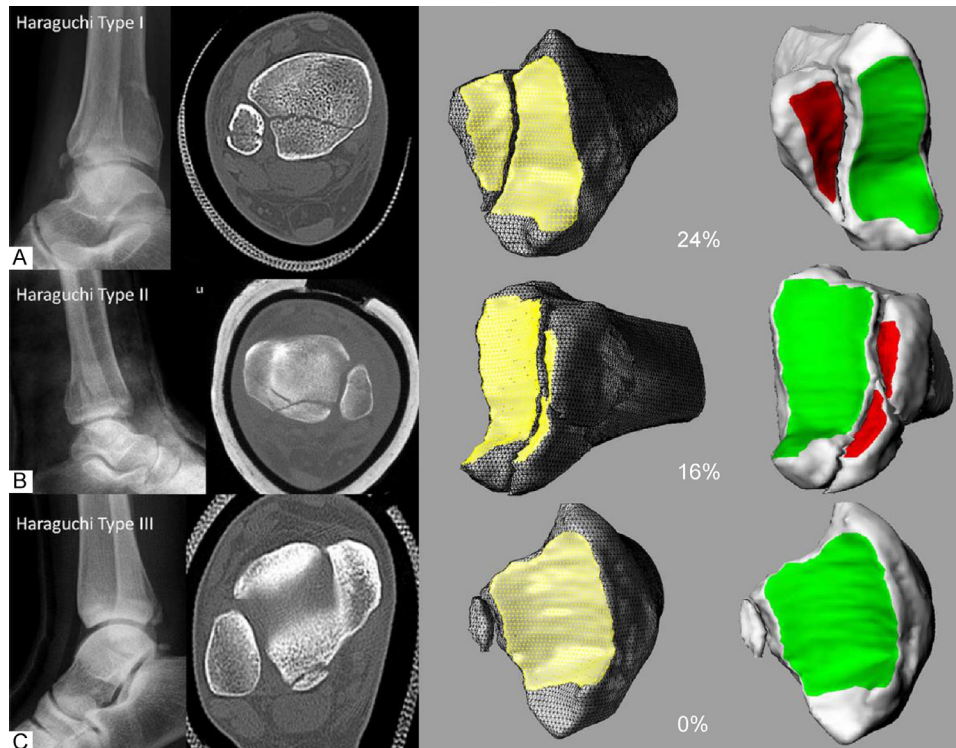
Haraguchi Classification System. Left: Plain lateral radiographic images and transverse CT images of ankle fractures, based on the original Haraguchi anatomic classification system of posterior malleolar fractures (25); Right: 3-dimensional CT-modeling images of ankle posterior malleolar fracture morphologies (showing percentages of articular surface involved in fracture) corresponding to the Haraguchi classification system, as described by Mangnus and colleagues (26). For both series of ankle images, A is right, B is left, and C is right. (Fig. 3 from Reference 26; License number 4799701090719, issued Mar 31, 2020, by Wolters Kluwer Health, Inc.)
